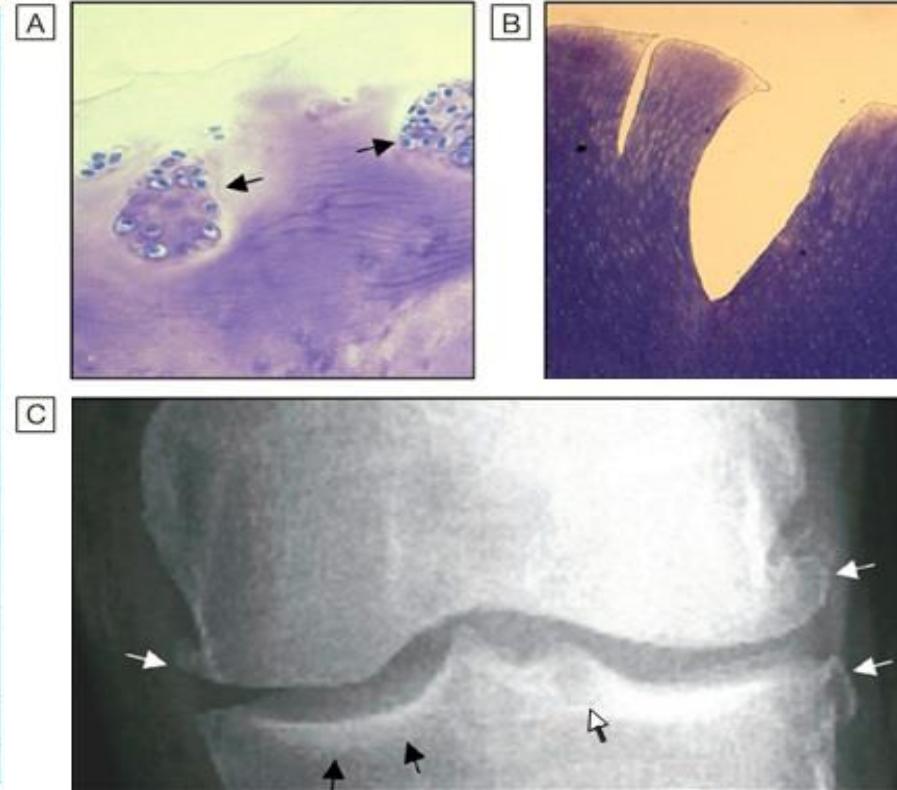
Pathological changes in osteoarthritis. A Abnormal nests of proliferating chondrocytes (arrows) interspersed with matrix devoid of normal chondrocytes. B Fibrillation of cartilage in OA. C Radiograph of knee joint affected by OA, showing osteophytes at joint margin (white arrows), subchondral sclerosis (black arrows) and subchondral cyst (open arrow).
